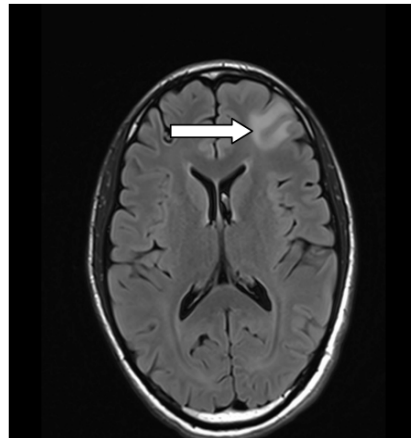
MRI-FLAIR axial non-contrast showing oedema
